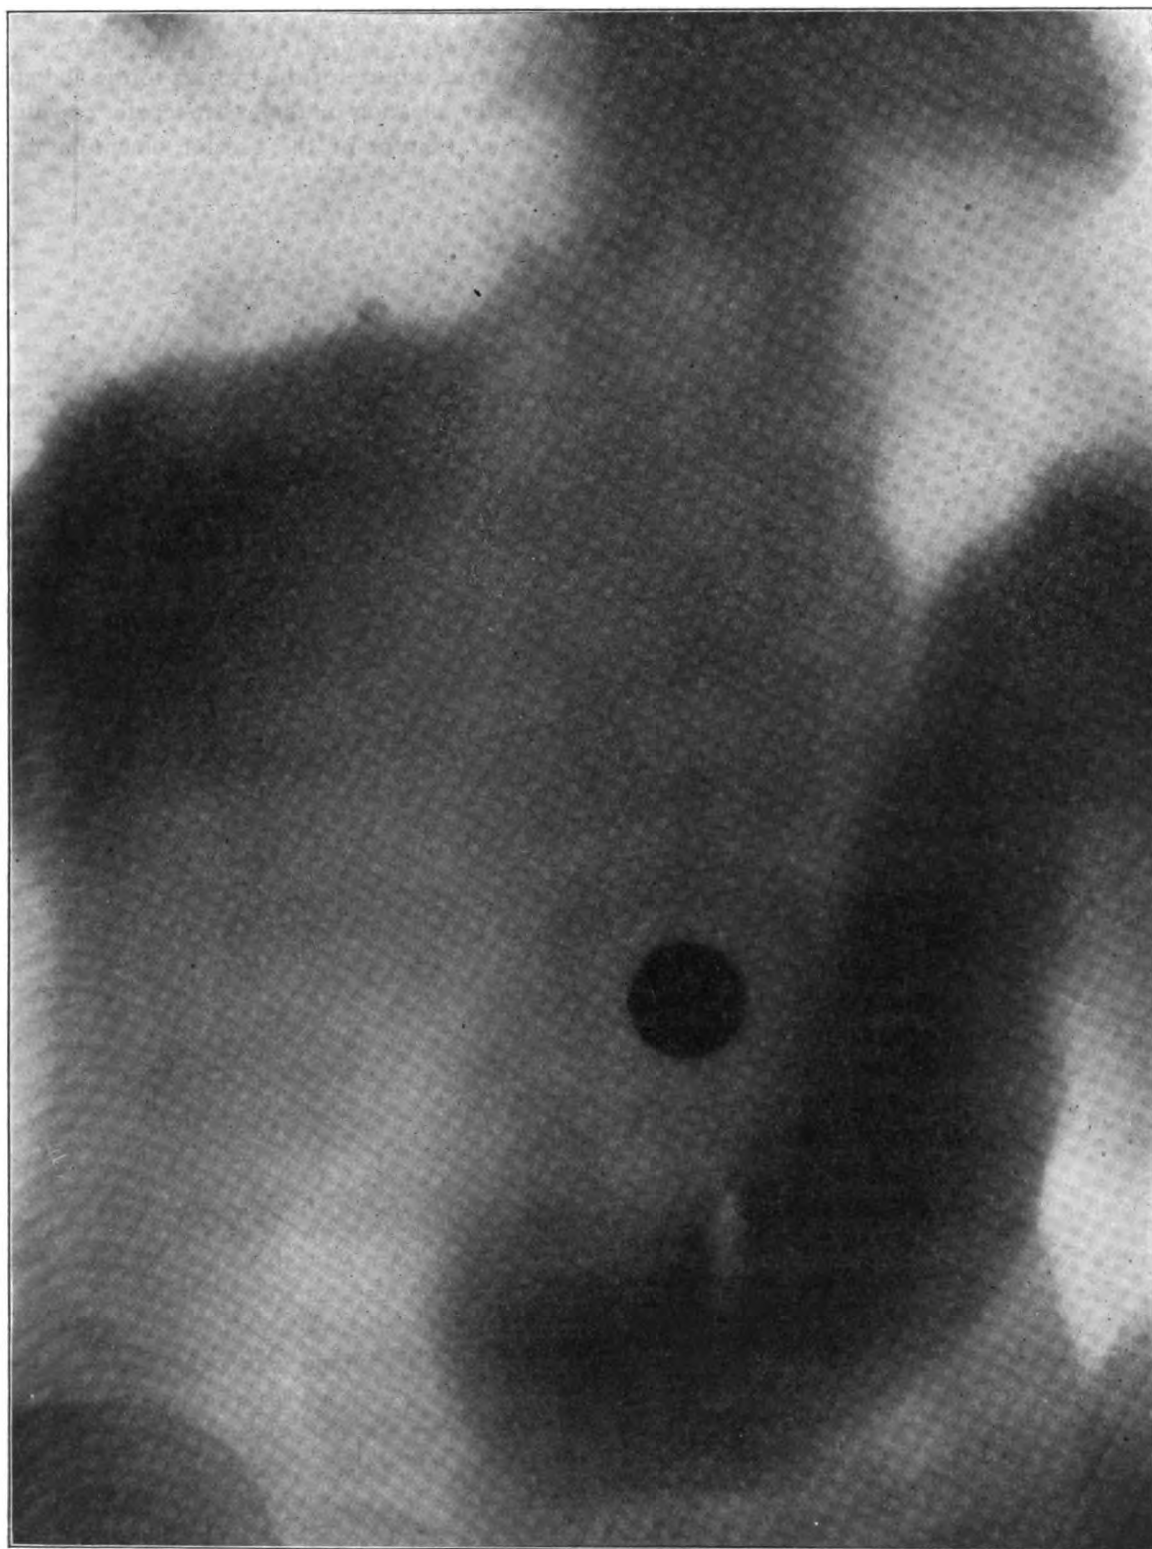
Radiograph of the stomach before operation taken in the recumbent position. In the erect posture the lower border of the stomach disappears below the brim of the pelvis.
